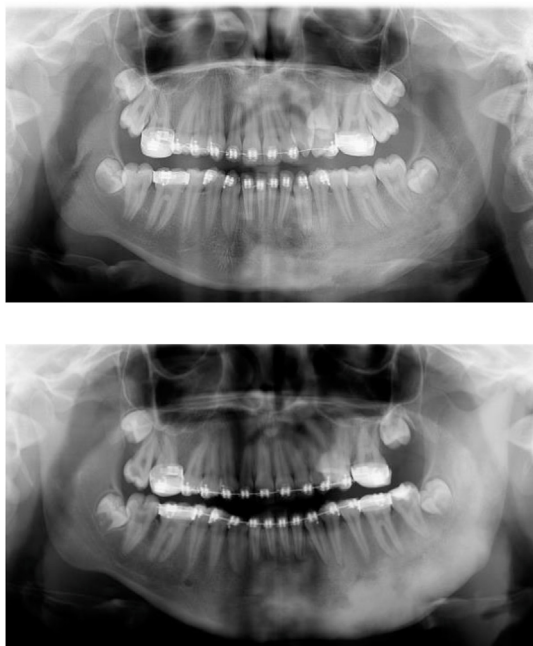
Pre- and post-treatment panoramic radiography of a 12-year-old patient with DSO/TP of the left mandible. The upper panoramic radiography is taken before the start of bisphosphonate therapy. The panoramic radiograph shows mixed lysis and sclerosis of the left mandibular ramus. The lowest panoramic radiography is taken 5.5 years after the first administration with bisphosphonates. It shows normalisation of the bone structures of the left mandibular bone.
